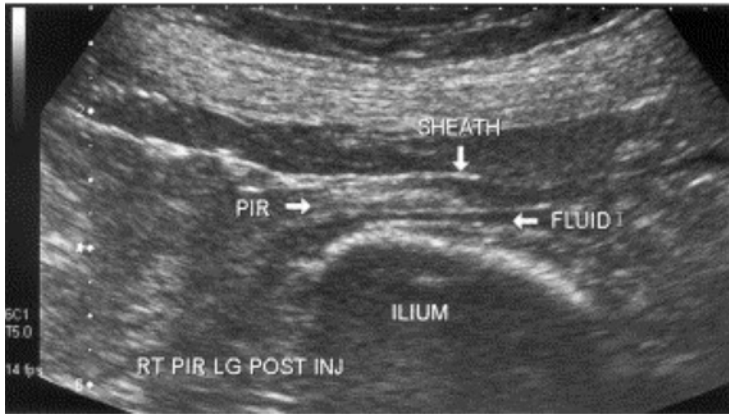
Piriformis Injection. Ultrasound is in-line with the piriformis and the needle is placed in the long axis from medial to lateral.
